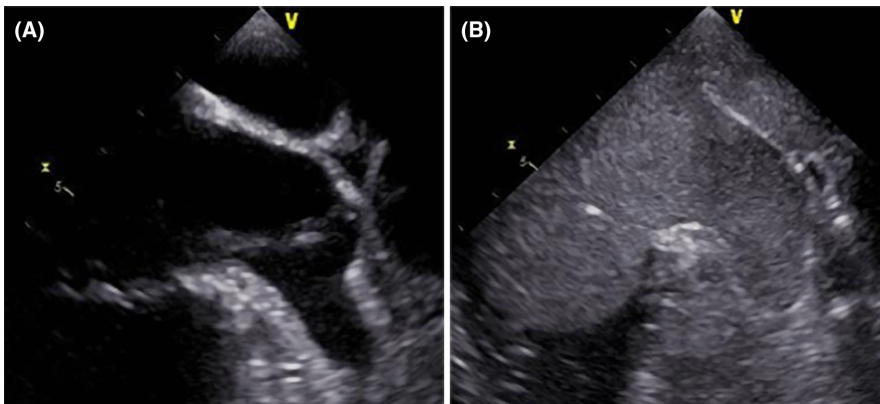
Pre- and post-contrast-enhanced transesophageal echocardiography evaluation of the left atrial appendage (LAA). The previously detected hyperechogenic material (A) has been suppressed by contrast echocardiography after complete opacification of the LAA cavity (B).
